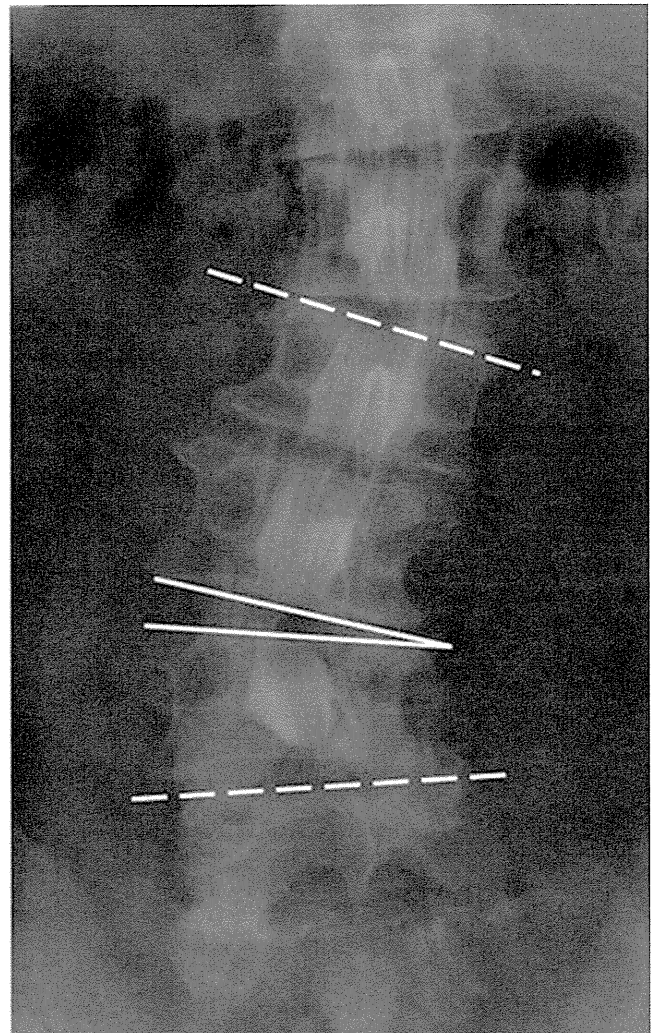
Radiographic parameters. Dotted lines indicate Cobb angle and solid lines indicate scoliotic wedging angle.
